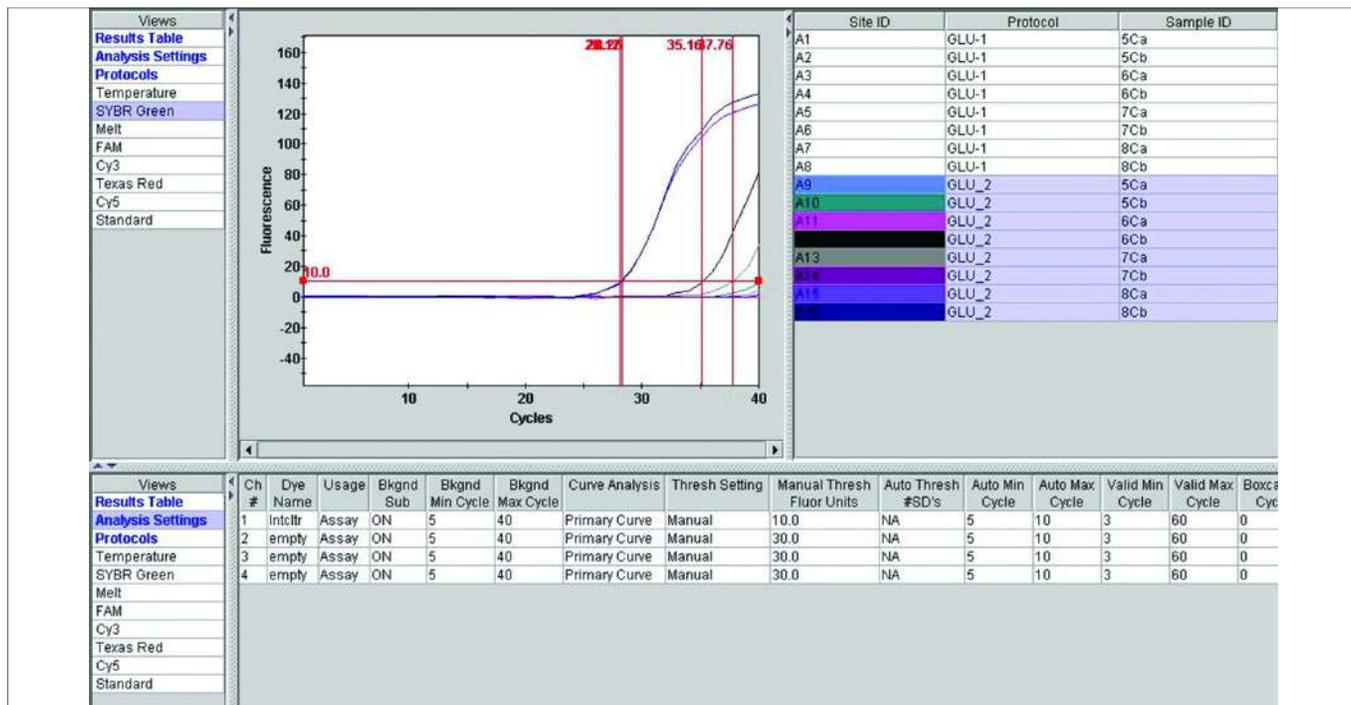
Curves showing cut off CT values of Glyoxalase II in enrolled patients. Graph showing CT values of Glyoxalase II.
